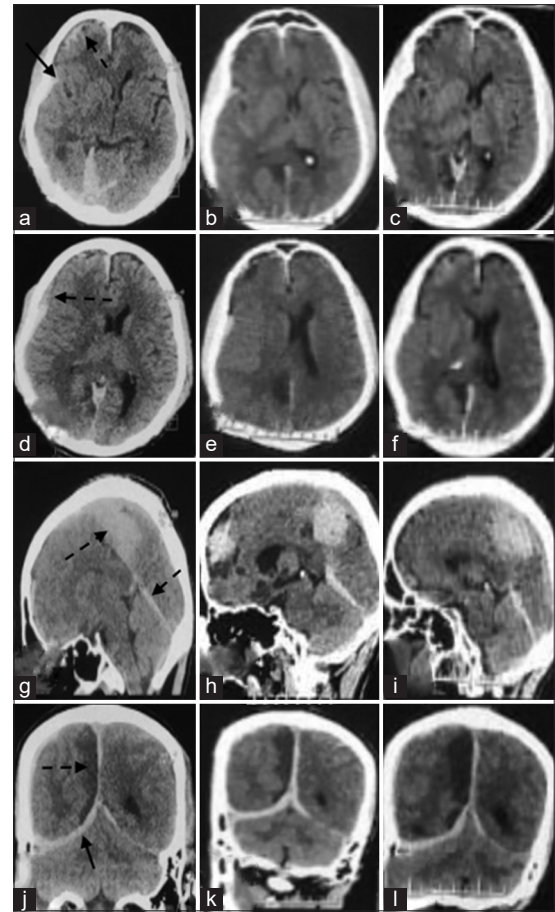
(a-c) Computed tomography scan of basal cuts showing SAH in the right sylvian fissure (arrow) and right frontal sulci (broken arrow) (a), gradually resolve in day 3 (b) and day 6 (c). (d-f) computed tomography scan of mid-axial section of the brain acute subdural hematoma with mixed density clot with hypodensity around it (broken arrow) (d), which disappeared in day 3 (e) and Day 6 (f). (g-i) Sagittal image showing redistribution of clot acute subdural hematoma along the tentorium and falx on (broken arrow) day 2 (g), day 3 (h) and day 6 computed tomography (i). (j-l) The coronal image showing day 2 (j), 3 (k) and 6 (l) showed almost similar size right PCA infarct (broken arrow)
